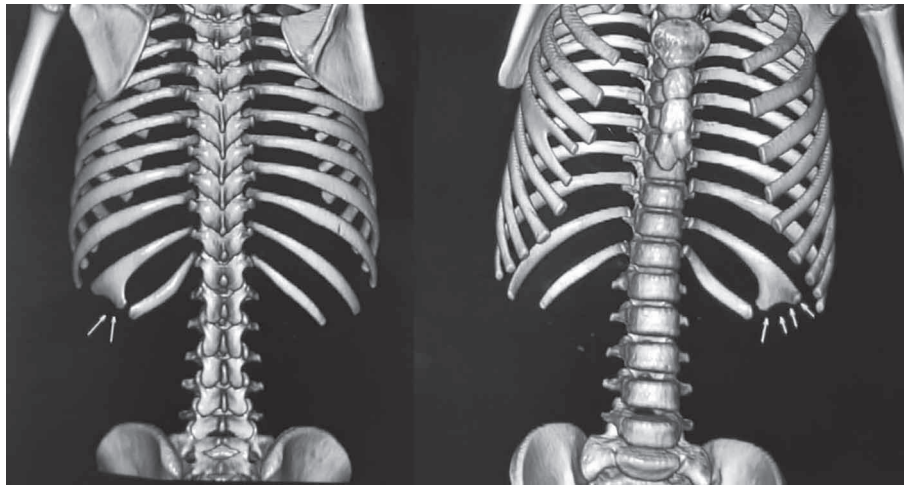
MRI picture of osteochondroma arising from rib
